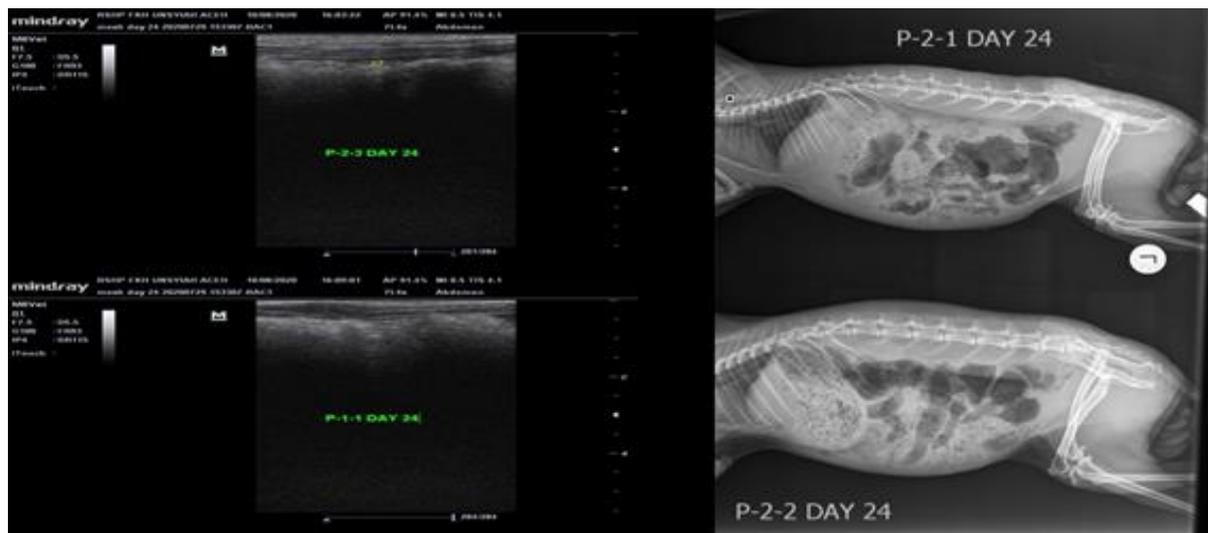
Rabbit ultrasonography and DR-Xray imaging of dorsal hypogastrium region around implanted area on day 24.
